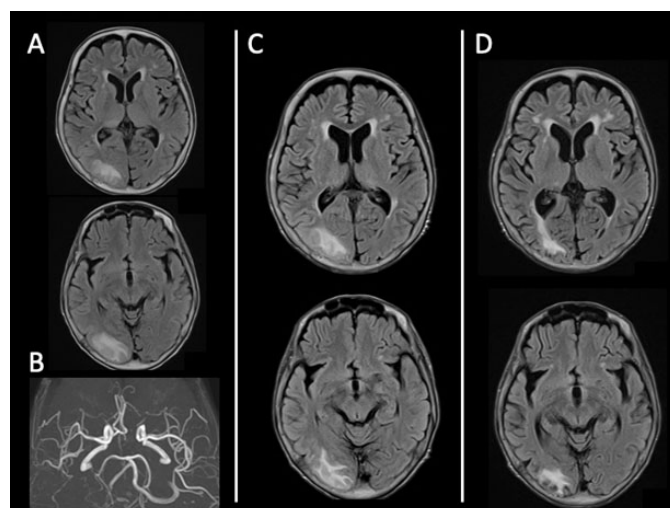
Head MRI (Case 3) (A) FLAIR at onset. (B) MRA at onset. There was no occlusion or stenosis of the vessels, including bilateral PCA. (C) FLAIR at seven days after onset. (D) FLAIR at five months after onset. MRI, magnetic resonance imaging; MRA, magnetic resonance angiography; FLAIR, fluid-attenuated inversion recovery.
